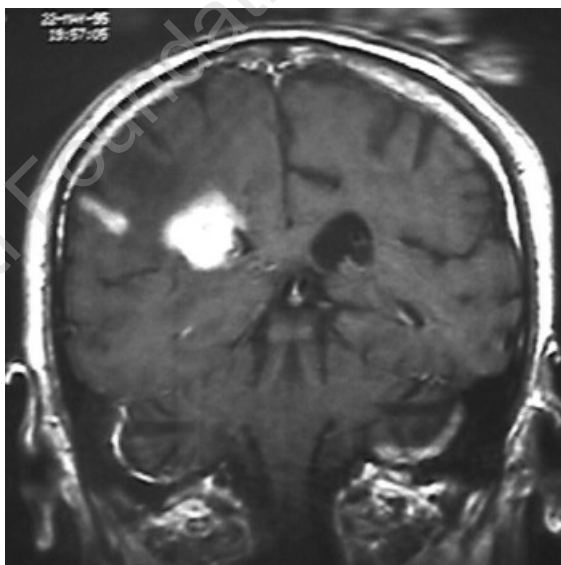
Magnetic resonance imaging of the brain after contrast infusion: a homogeneously enhanced lesion with polylobated limits in the deep left temporal area infiltrating the ventricular trigone, with evident perilesional edema can be seen.
